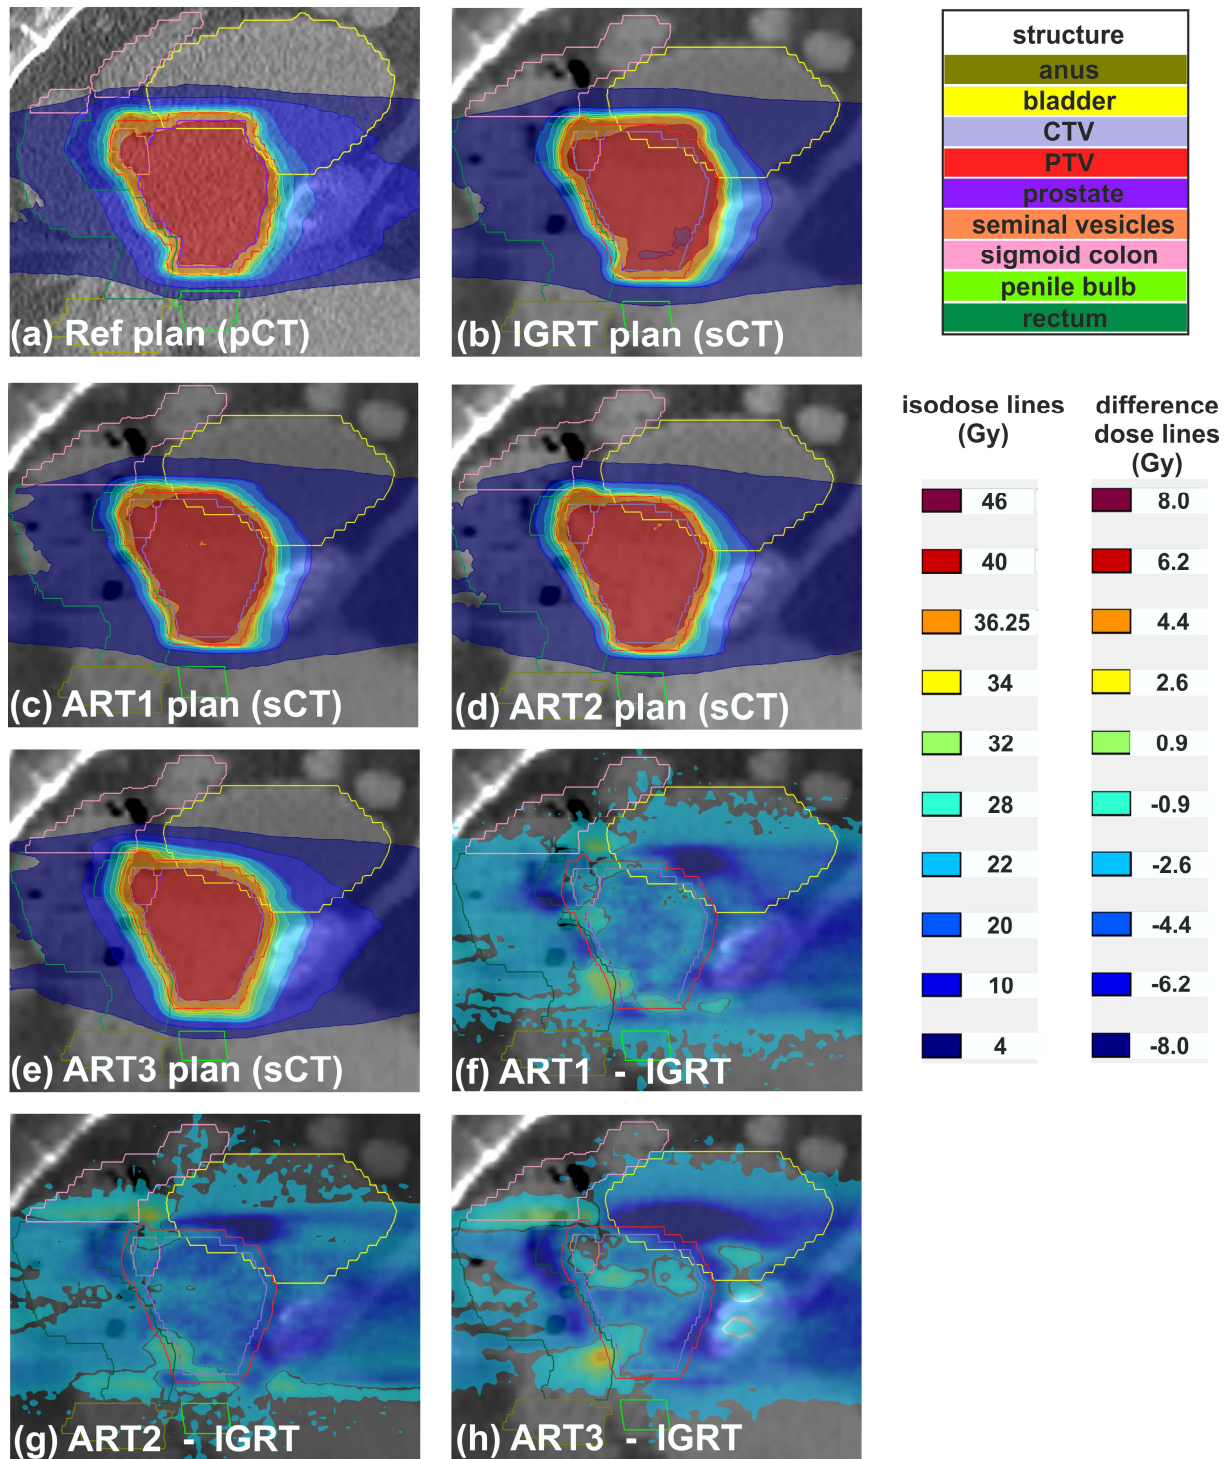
Exemplary sagittal dose distributions of the reference plan on the planning CT (pCT) (a), of the ART3 plan on the synthetic CT (sCT) (b) and of the IGRT plan on the sCT (c). Dose difference maps between the IGRT approach and the three adaptive approaches on the sCT (d-f) revealed anatomical regions in the rectum, bladder and soft tissue with dose differences of up to 8 Gy. Prescription doses were $D(CTV)=40$ Gy and $D(PTV)=36.25$ Gy. A low dose threshold of 1% referring to 60 Gy was used for the dose difference maps.
